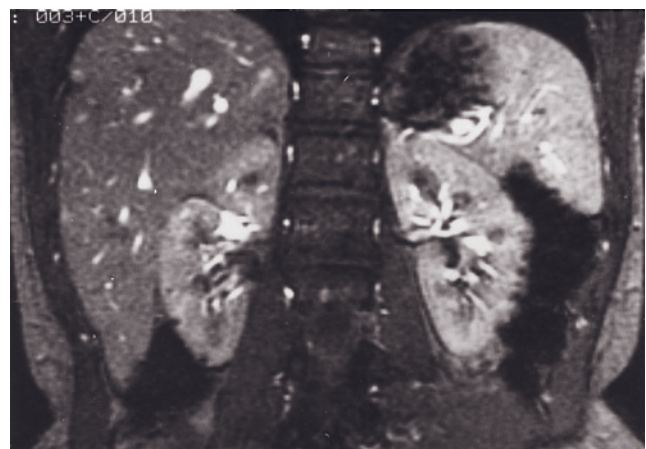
Renal trauma. T1-weighted precontrast (*a*) and 90-s gadolinium-enhanced (*b*) fat-suppressed SE images. High-signal-intensity perirenal hematoma is present surrounding an enlarged left kidney on the precontrast image. The interstitial-phase gadolinium-enhanced image demonstrates greater enhancement of the left kidney, compared to the normal right kidney. This excludes renal artery compromise but implies increased intrarenal tissue pressure, capillary leakage, and/or renal vein compromise. T1-weighted precontrast SGE (*c*), T2-weighted SS-ETSE (*d*), T1-weighted immediate postgadolinium SGE (*e*), and sagittal 90-s fat-suppressed postgadolinium SGE (*f*) images in a second patient who sustained abdominal trauma. High-signal-intensity hemorrhage is noted in the perirenal and posterior pararenal space in the left kidney with a multilayered appearance (*c*). Mixed high signal intensity is apparent on the T2-weighted image (*d*), which is consistent with blood products of varying age. In addition, a tubular-shaped focus of high signal intensity is present, a finding consistent with an intraparenchymal laceration (arrow, *d*). The kidney enhances normally immediately after contrast administration, excluding a major renal arterial injury. The sagittal image (*f*) demonstrates the full renal length and the volume of posterior pararenal blood (arrows).
